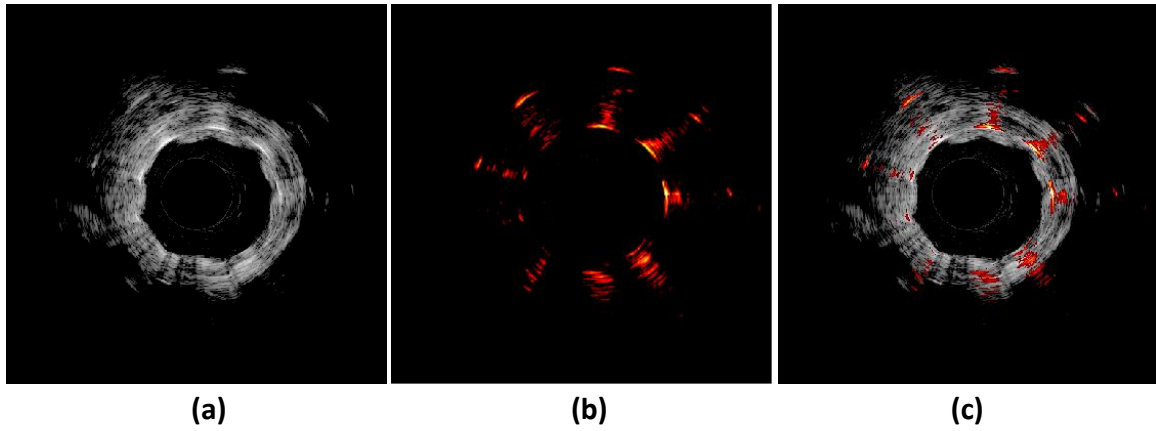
(a) Ultrasound (IVUS) and (b) photoacoustic (IVPA) cross-sectional images of the stent deployed within an excised rabbit artery. (c) Overlay of the two images together shows the position of the stent struts with respect to the thickness of the vessel wall. US and PA images are displayed at 55dB and 25 dB, respectively.
